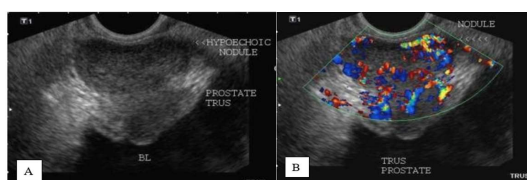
A Prostatic adenocarcinoma: Transrectal ultrasound axial shows a hypoechoic lesion involving most of leftperipheral zone. B: Colour Doppler TRUS images reveals marked vascularity in the region of thenodule seen in the left peripheral zone.
